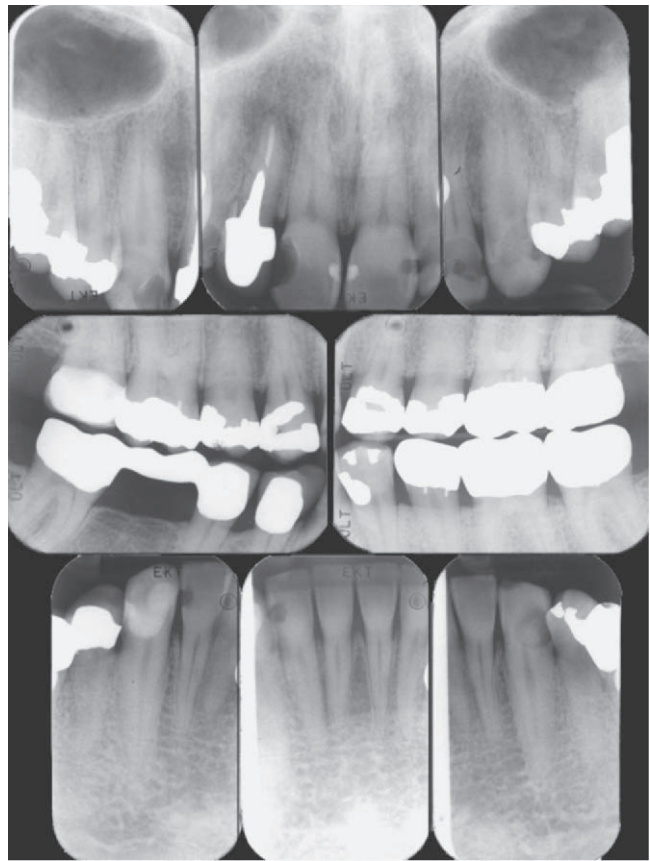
Patient with numerous large restorations who remains at risk for caries—a prime indication for taking radiographs more frequently. (Courtesy Dr. J. Ludlow, Chapel Hill, NC.)
